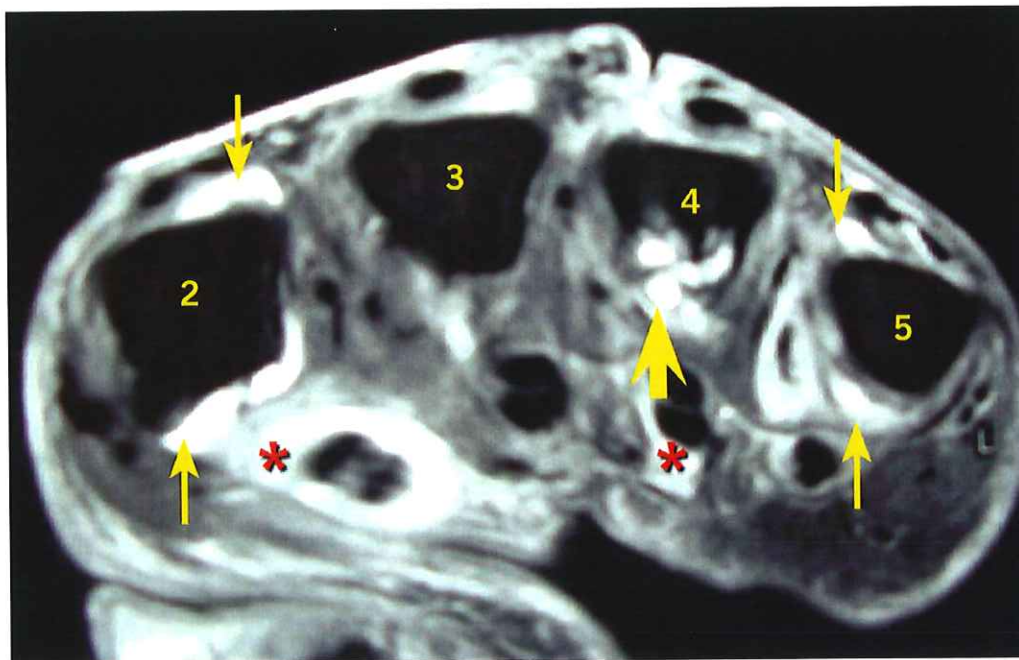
(c) Post-gadolinium MRI of left 4th MCP joint clearly shows bone defect and erosion of volar aspect of MC head with gadolinium enhancement (thick arrow). Additionally, there is second and fourth finger FT (*) and synovitis of second and fifth MCP joints (thin arrows)
